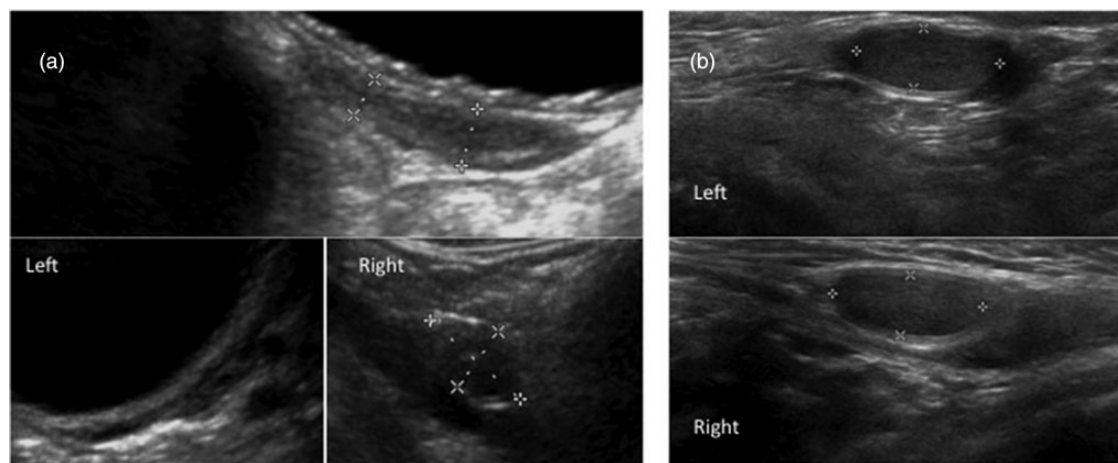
Images of ultrasound scans: (a) Scan of Twin 2, 5 years of age, showing normal uterus and two ovaries. (b) Scan of Twin 1, 5 years of age, showing normal testicles (cross and dotted lines were used for measure).
